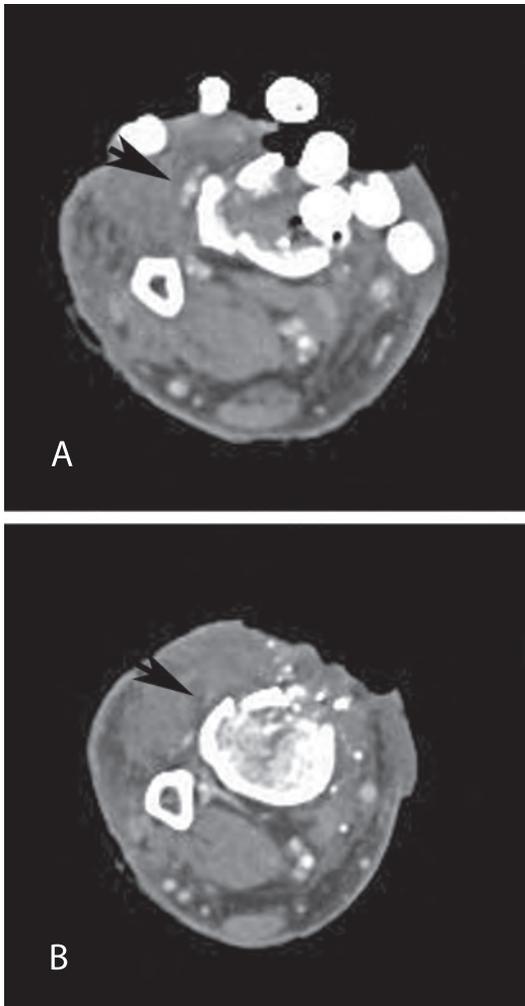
Computed tomographic angiography scans of a 54-year-old man with a comminuted tibial fracture and anterior soft-tissue defect over the right leg. *A*, Patent anterior tibial arterial and venous comitantes at the proximal margin of the injury site (arrow) are shown. *B*, Image obtained 4 cm distal to the image shown in *A* shows occlusion of anterior tibial vessels, evidenced by the absence of contrast (arrow). (Reprinted with permission from Duymaz et al.³⁸²)
